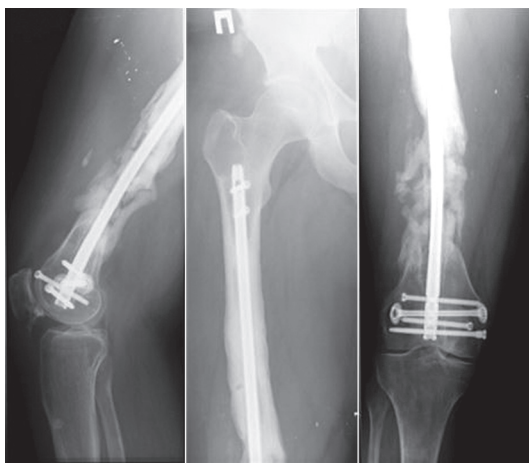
Radiographs of the right femur of patient L., 27 years old, 6 months after the injury
